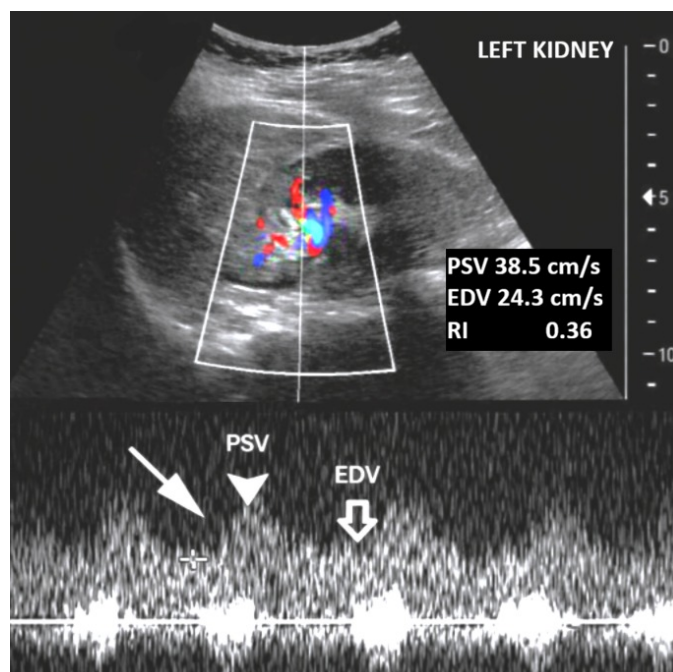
Doppler ultrasound image showing parvus tardus waveform in left superior interlobar artery with RI of 0.36
